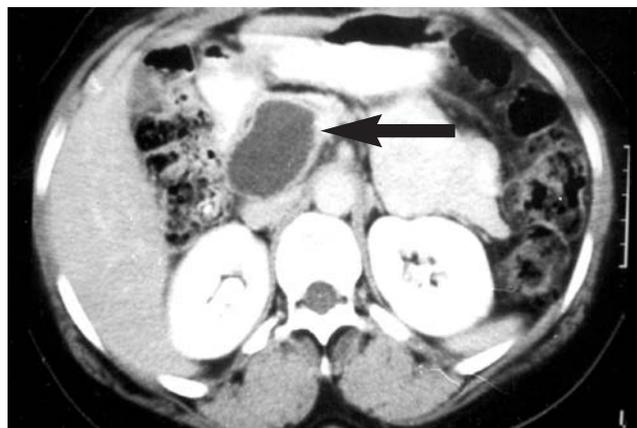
CT scan: 4 cm unilocular cystic mass (arrow) in the head of the pancreas.
